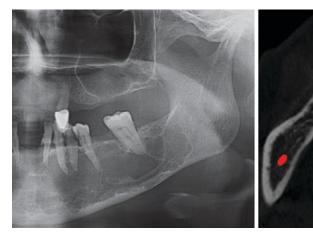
Mucoepidermoid carcinoma. (a) Cropped OPG reveals a well-defined multilocular lesion extending between mandibular midline to mandibular right postmolar site. Thin septa formations are seen. (b) CBCT Axial
